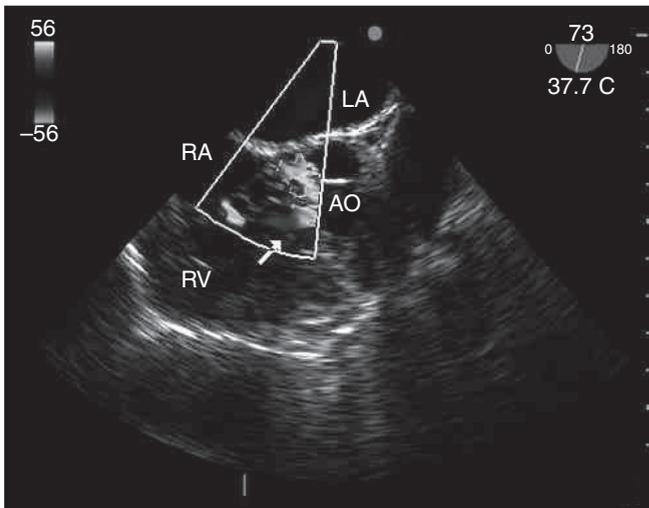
Short axis aortic view with multiplane of 73°. Color Doppler mapping shows the flow (white arrow) from the subaortic region to the right ventricle.
